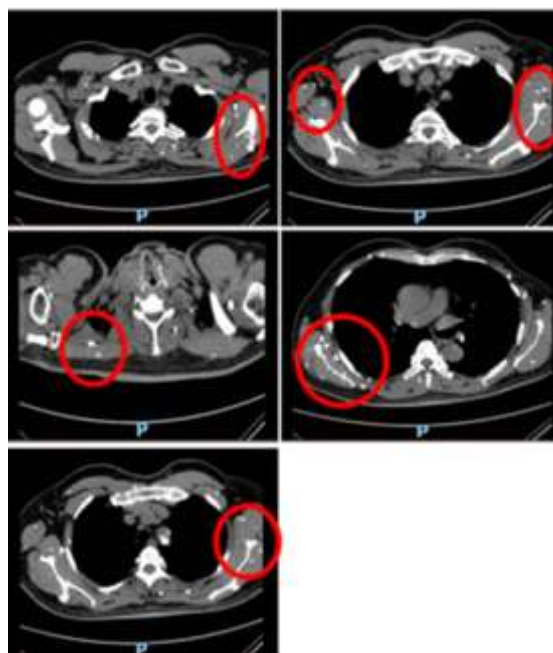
Chest CT. Multiple rice grain calcification (red circle).
